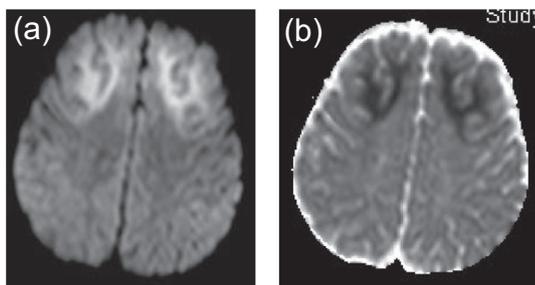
Typical bright tree appearance with frontal predominance is shown in a patient with AESD. Shown here are (a) diffusion weighted imaging (DWI) and (b) apparent diffusion coefficient (ADC). Abnormal hyperintensity in DWI associated with a decreased ADC suggested cytotoxic edema.
